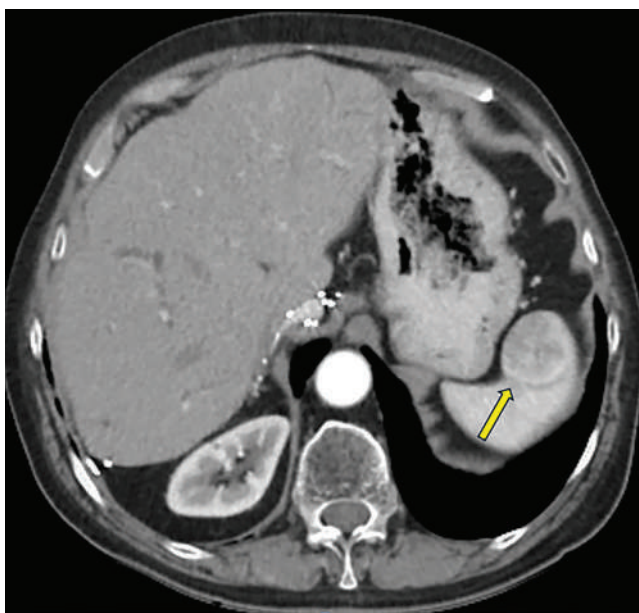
Splenic recurrence of HCC after liver transplantation: on contrast-enhanced axial CT, a splenic mass consistent with recurrent hepatocellular carcinoma is observed. The lesion is indicated by the yellow arrow.
